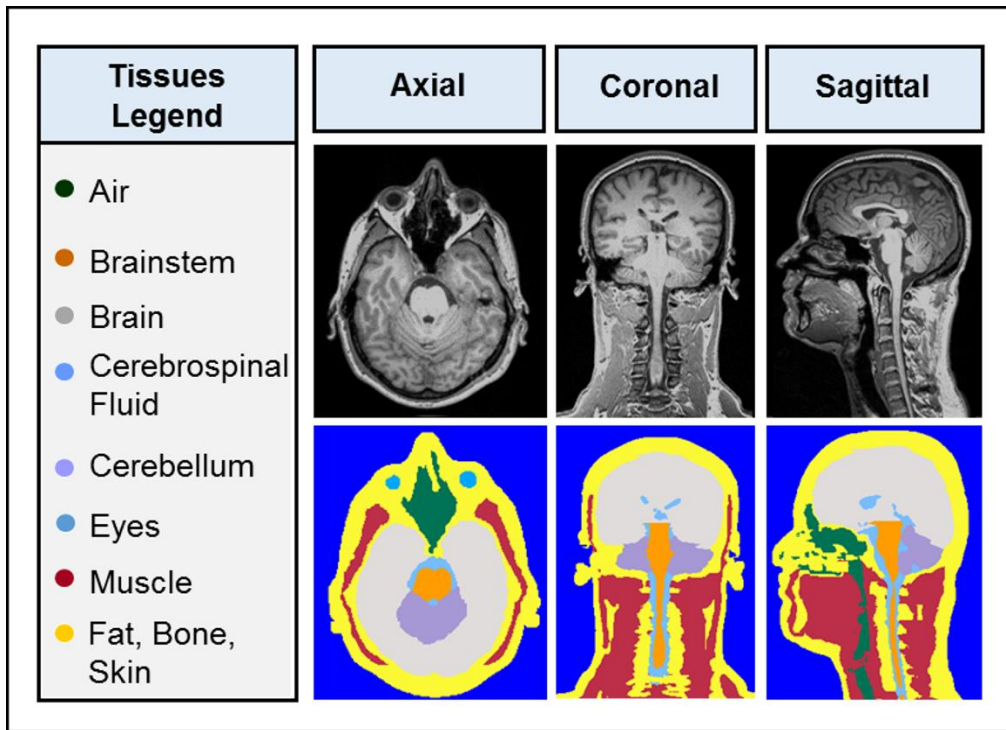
Medical Data Acquisition and Segmentation. A 3T MRI scan with $1.0 \times 1.0 \times 1.0 \text{ mm}^3$ resolution was segmented and divided into eight individual tissues. Each segmented tissue is listed with the corresponding tissue segmentation color within the tissue legend. The pictured MRI dataset and segmented tissues are shown in the mid axial, coronal and sagittal views. Table 3.1 lists the physiological tissues that were used to classify the tissues in the legend.
